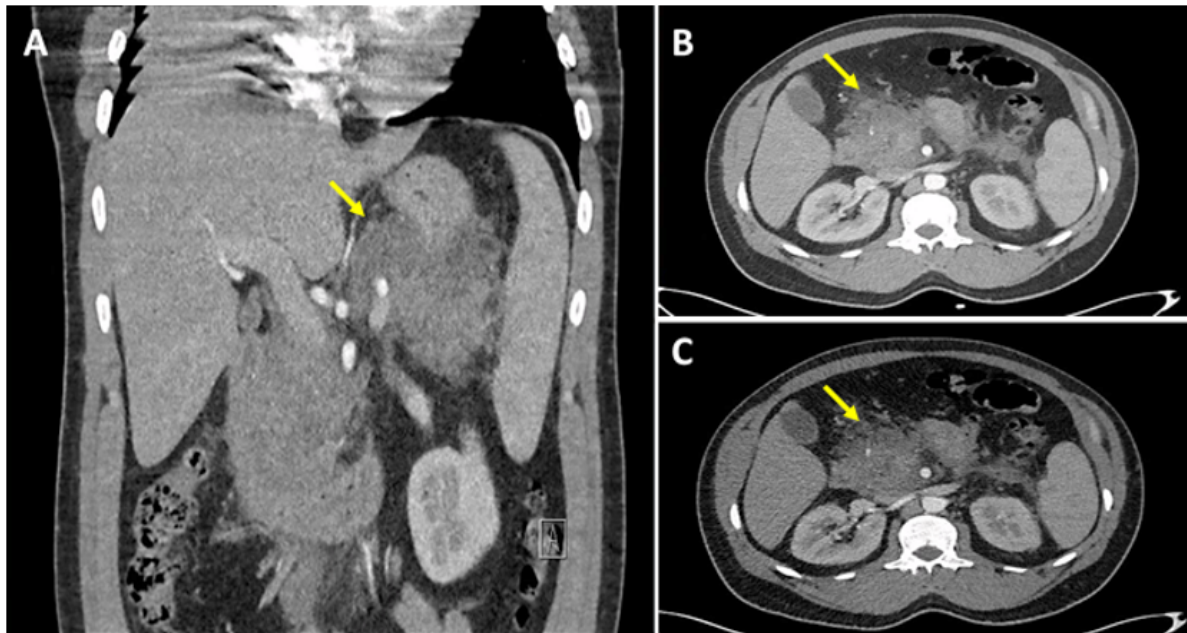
Injcted abdominal CT-Scan showing acute necrotizing pancreatitis in coronal (A) and horizontal section (B and C) associated with several acute necrotic collections (Yellow Arrow).
